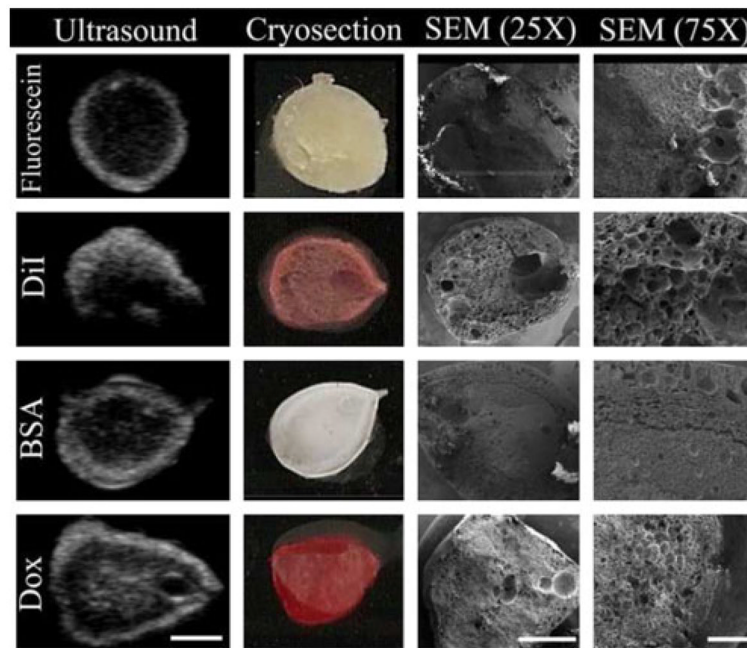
Validation of implant morphology ultrasound data. Shown are representative images from ultrasound (Day 3, *scale bar*=2.5 mm), digital camera, SEM ($\times 25$ magnification, *scale bar*=2 mm), and higher magnification SEM ($\times 75$ magnification, *scale bar*=500 μm)
